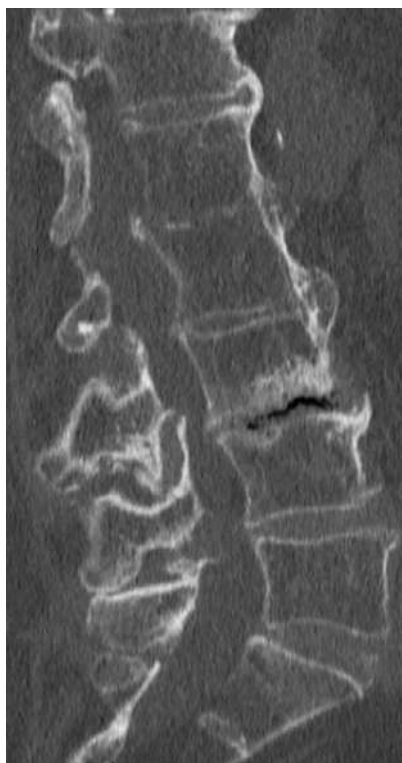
Baastrup syndrome on sagittal CT-scan
